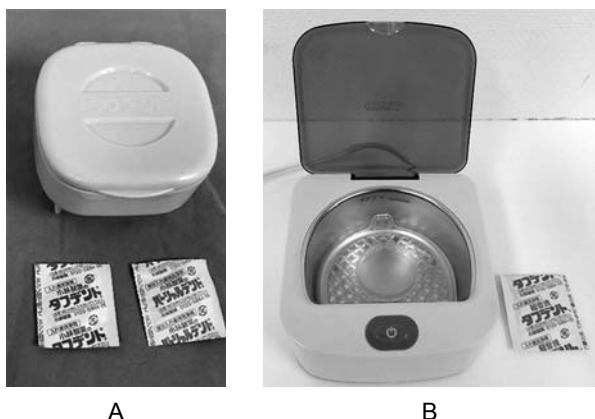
Denture cleaning methods. (A) With the immersion method the denture is placed in a storage cup with the cleaning solution at 40°C or 15°C for 30 min. A tablet for either a complete (left) or partial (right) denture is dissolved in water to make the solution. (B) With the commercial ultrasonic denture cleaner, the prosthesis is immersed in a solution at 15°C for 5 min.
